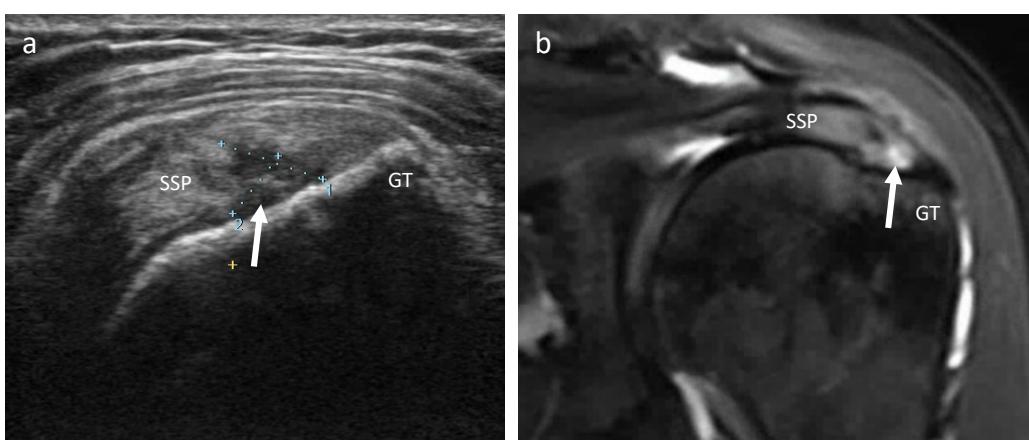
Partial-thickness supraspinatus tear. (a) Ultrasound (long axis) showed an articular side tear (arrow) of the supraspinatus tendon (SSP). (b) The oblique coronal T2-weighted fat-suppressed MRI showed the same configuration of the partial-thickness tear (arrow) of the supraspinatus tendon (SSP). Abbreviations: GT = greater tuberosity
